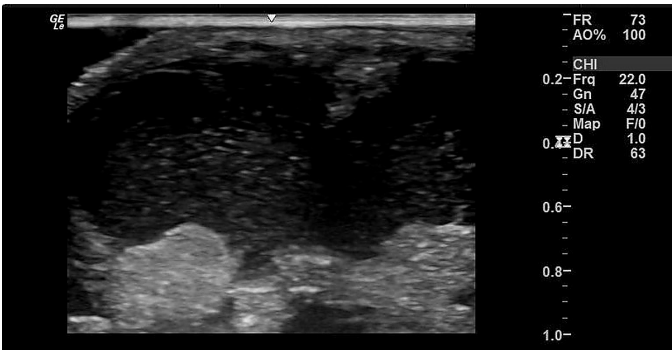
12-MHz ultrasonography: “fluid-fluid level.”
